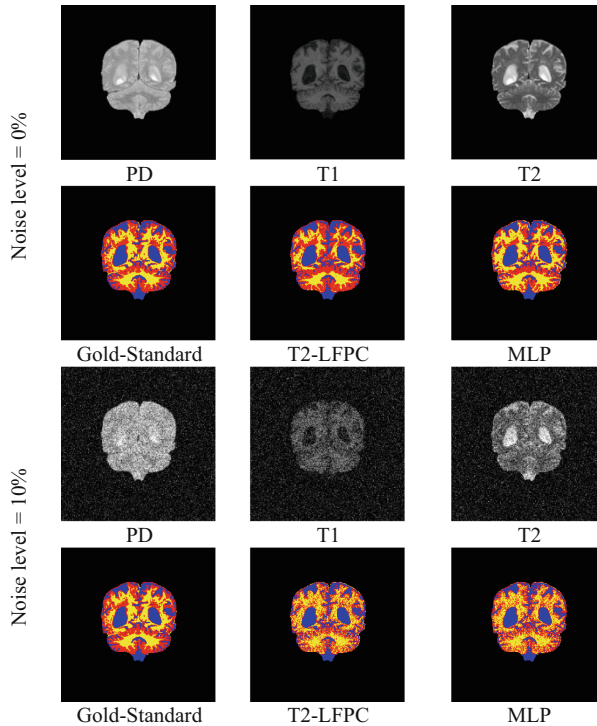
Input images, Gold-Standard, and results obtained for one of the images of the dataset #2 (real MRI) for noise levels of 0%, and 10%.
